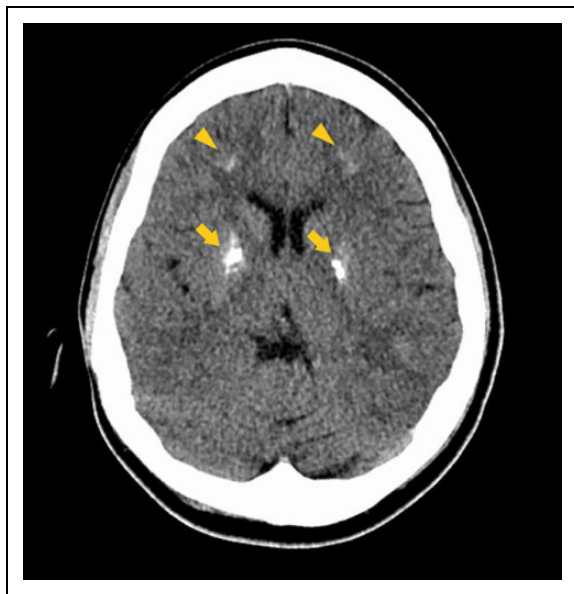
Computed tomography of our patient's brain showing dense calcification in the bilateral globi pallidi (arrows) and subtle calcification (arrowheads) in the bilateral frontal white matter.
